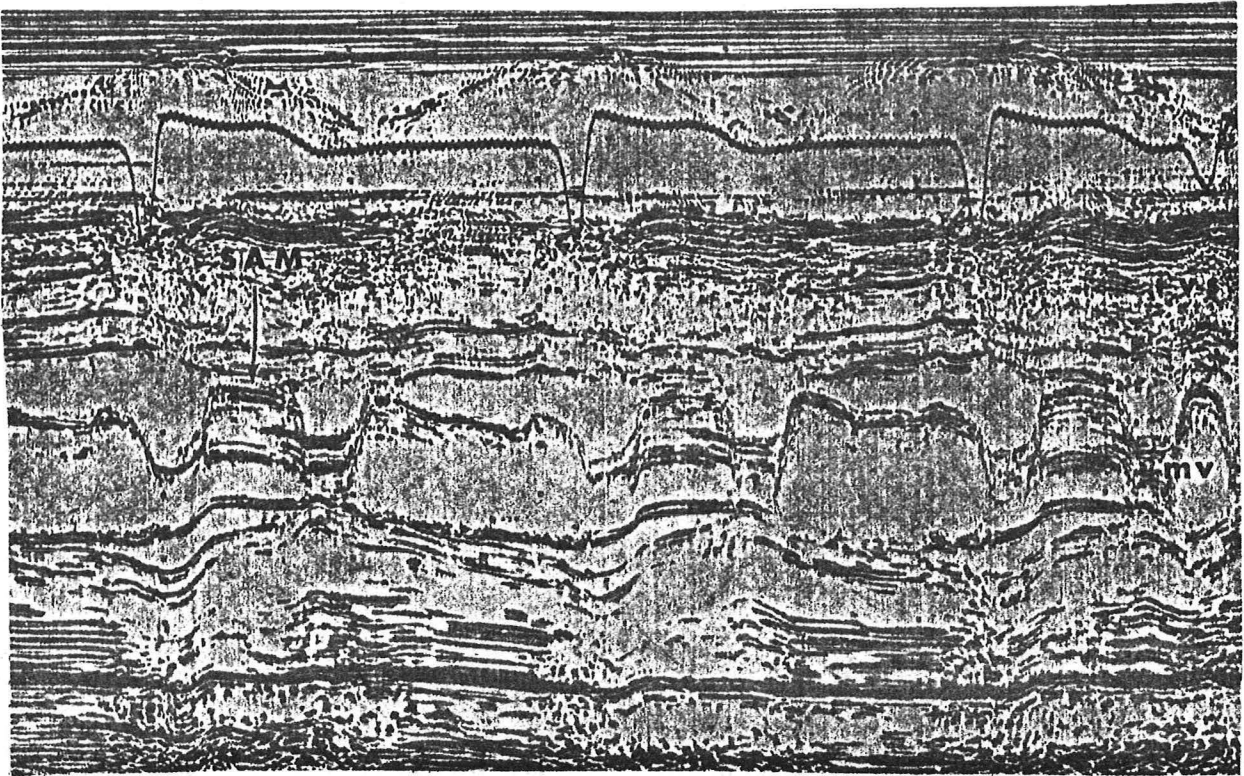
Echocardiogram of a patient with asymmetric septal hypertrophy showing disproportionate hypertrophy of the interventricular septum (IVS) and systolic anterior motion (SAM) of the anterior leaflet of the mitral valve.
